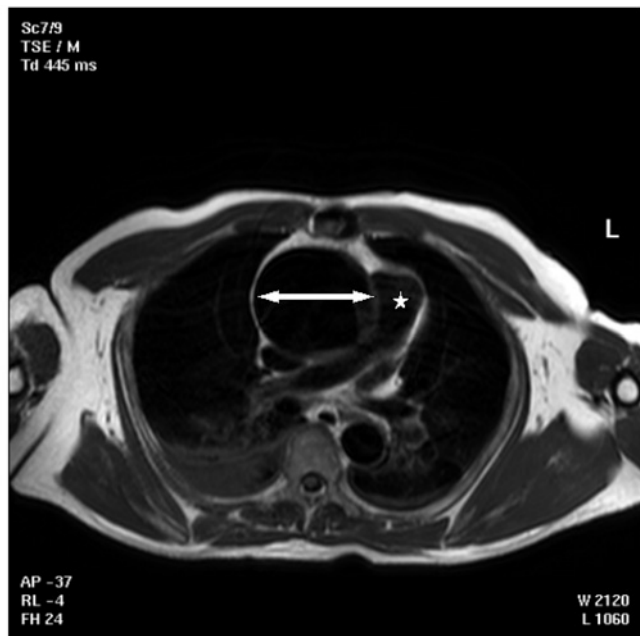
Magnetic resonance image of the large ascending aortic aneurysm (bounded by the arrows). The asterisk marks the main pulmonary artery.
